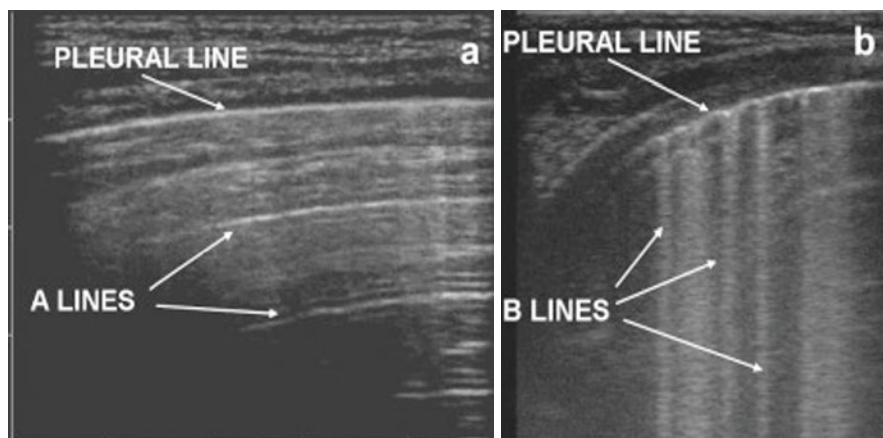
Lung ultrasound A line and B lines
